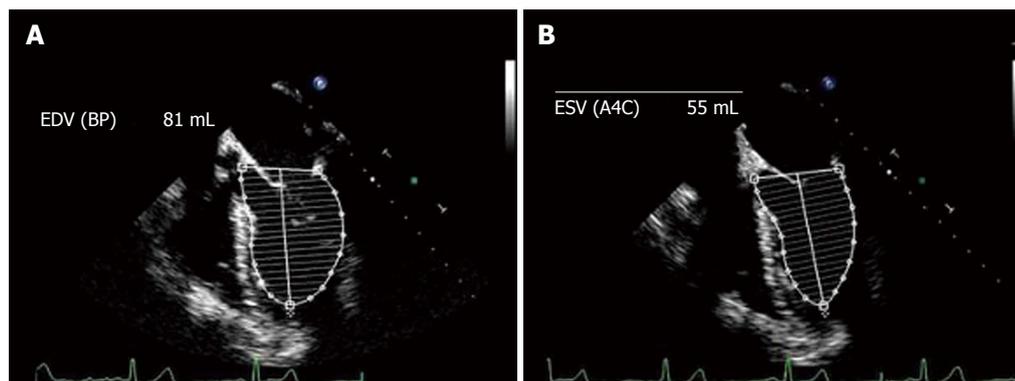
Calculation of ejection fraction using the disc method (Simpson's rule). Transoesophageal echocardiography ME 4C view in diastole (A) and systole (B). The bidimensional image is usually best imaged at a multiplane angle of 0°. Modified by Guarracino Fabio *et al*^[61]. EDV: End diastolic volume; ESV: End-systolic volume.
